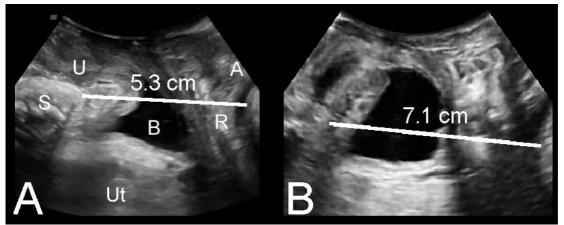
Determination of midsagittal hiatal diameter on 2D translabial ultrasound (oblique lines). A: 5.3 cm (normal) in patient with Cystocele I and stress incontinence, B: 7.1 cm (marked ballooning) in patient with 2nd degree anterior and posterior compartment descent. S= symphysis pubis, Ut= uterus, U= urethra, B= bladder, R= rectum, A= anal canal.
